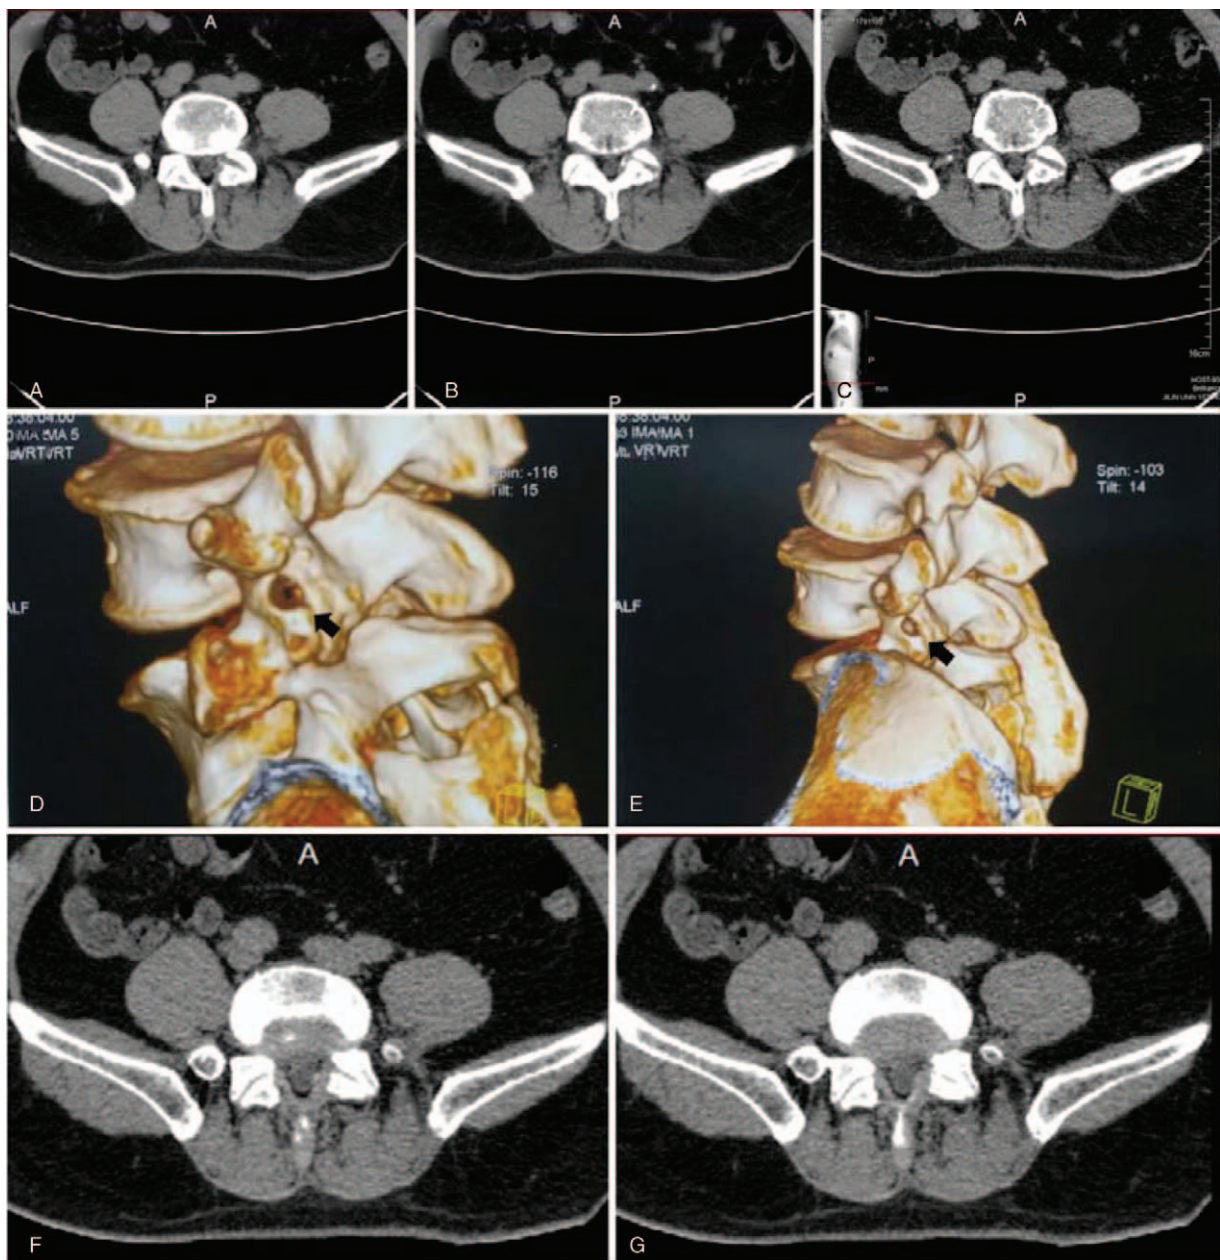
Postoperative CT shows the working tract through the left facet joint (A–C). Three-dimensional CT revealed that the passage (black arrow) was made through the facet capsule (D and E). Postoperative CT demonstrates the decompressed dural sac and restored spinal canal (F and G). CT = computed tomography.
